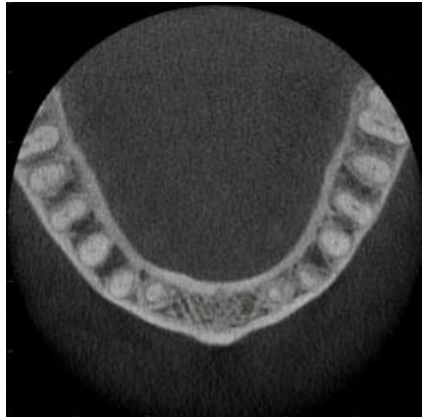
Axial CBCT image at a coronal position
